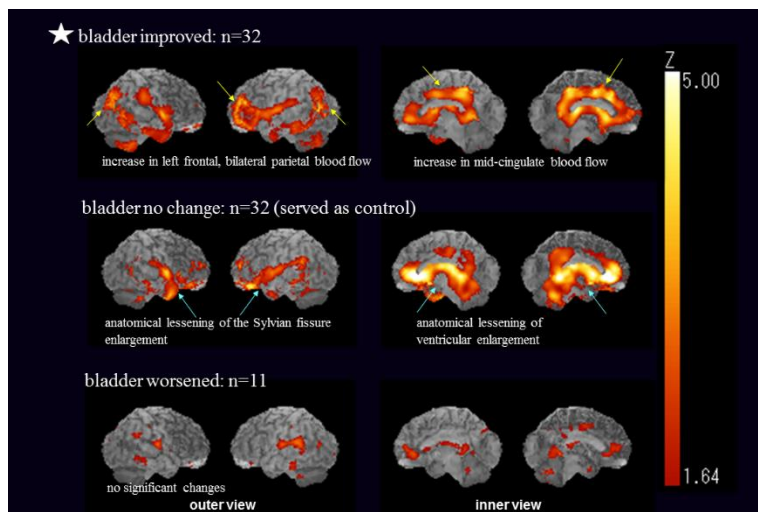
3D-SSP statistical analysis results of brain SPECT scan of NPH patients between post versus pre shunt surgery. N=75.
